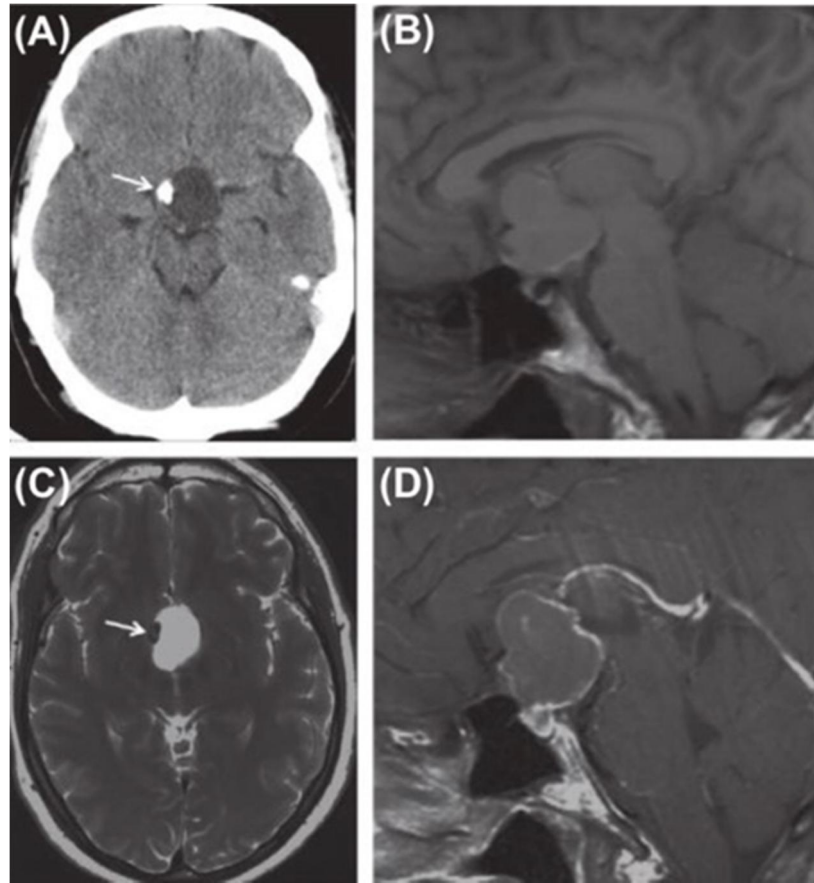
A, Axial, non- contrast CT image shows a hypo dense, suprasellar cystic mass measuring 20 Hounsfield units in density, with a peripheral, nodular focus of calcification (arrow). The calcification is not typically seen with a Rathke cleft cyst. B, Sagittal, T1-weighted MR image shows a lobulated, moderately hyper intense, suprasellar mass. C, Axial, T2- -weighted MR image shows focal hypo intensity (arrow) corresponding to the calcification seen on CT imaging. D, Sagittal, T1-weighted enhanced MR image shows peripheral enhancement of the mass. The enhancement is not typically seen with a Rathke cleft cyst
